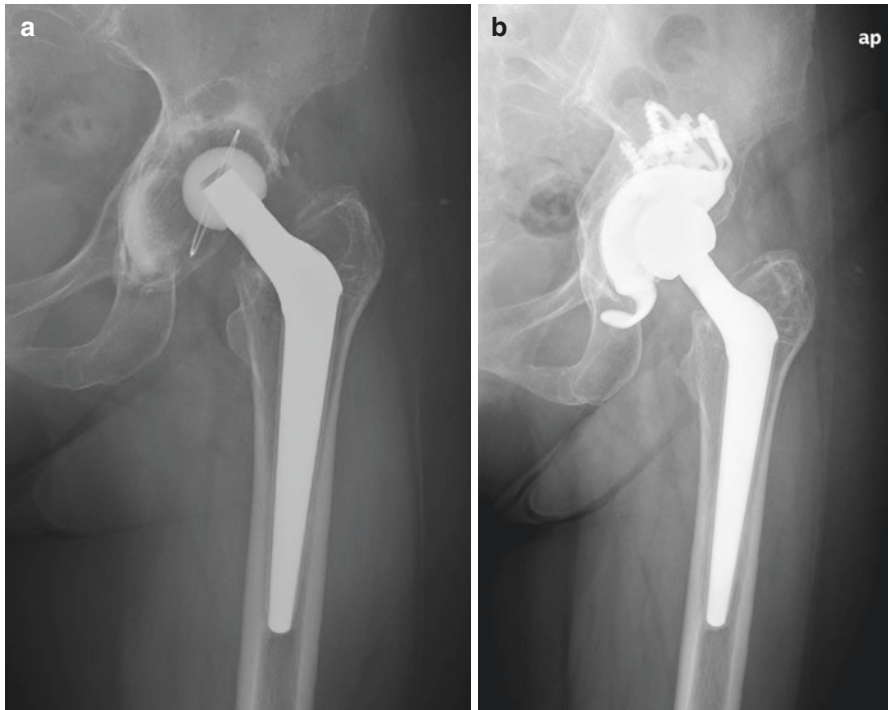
(a) Preoperative radiograph shows a loosened cemented cup. (b) A metallic cage was used in revision surgery with a good clinical outcome
